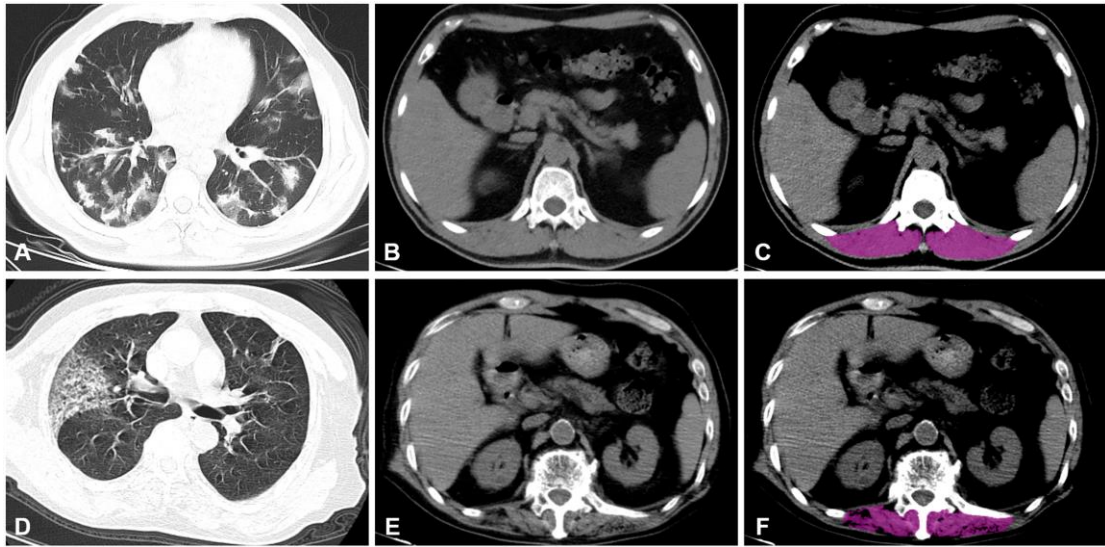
CT images showing the pulmonary involvement and paraspinal muscle measurements in two patients with severe COVID-19 pneumonia. (A) A 56-year-old male patient with multiple, patchy ground-glass opacity or consolidation in bilateral lungs; (B) CT image at the T12 level used for the paraspinal muscle measurement; (C) Purple zone indicating the paraspinal muscle area identified using a threshold of -29 to +150 HU (PMI 13.0 cm<sup>2</sup>/m<sup>2</sup>, PMD 48.6 HU). (D) A 70-year-old male patient with large patchy ground-glass opacity with crazy-paving sign in right lung; (E) CT image at the T12 level used for the paraspinal muscle measurement; (F) Purple zone indicating the paraspinal muscle area identified using a threshold of -29 to +150 HU (PMI 10.3 cm<sup>2</sup>/m<sup>2</sup>, PMD 25.6 HU).
